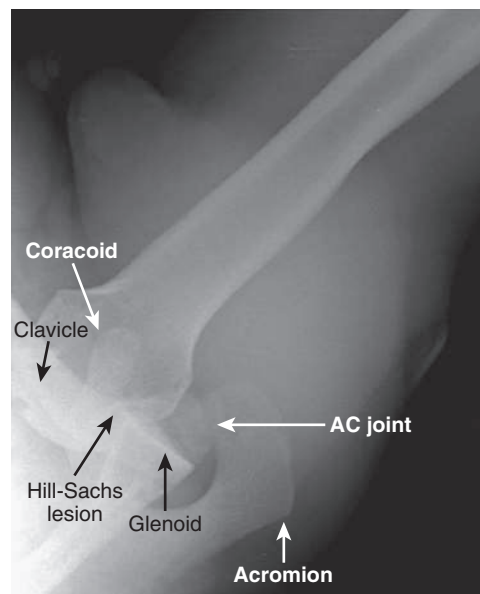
Axillary lateral radiograph demonstrating anterior glenohumeral dislocation that resulted following a fall while the patient was skiing in the backcountry.
